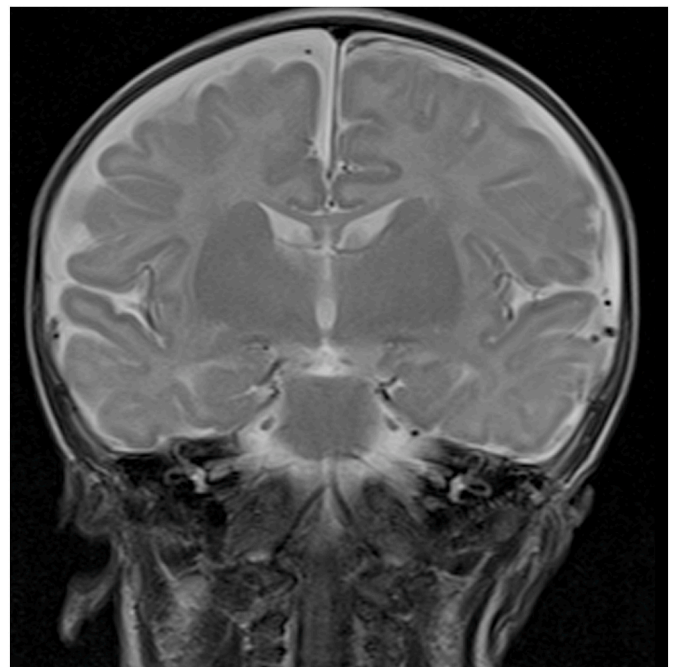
T2 Coronal MRI of brain.
